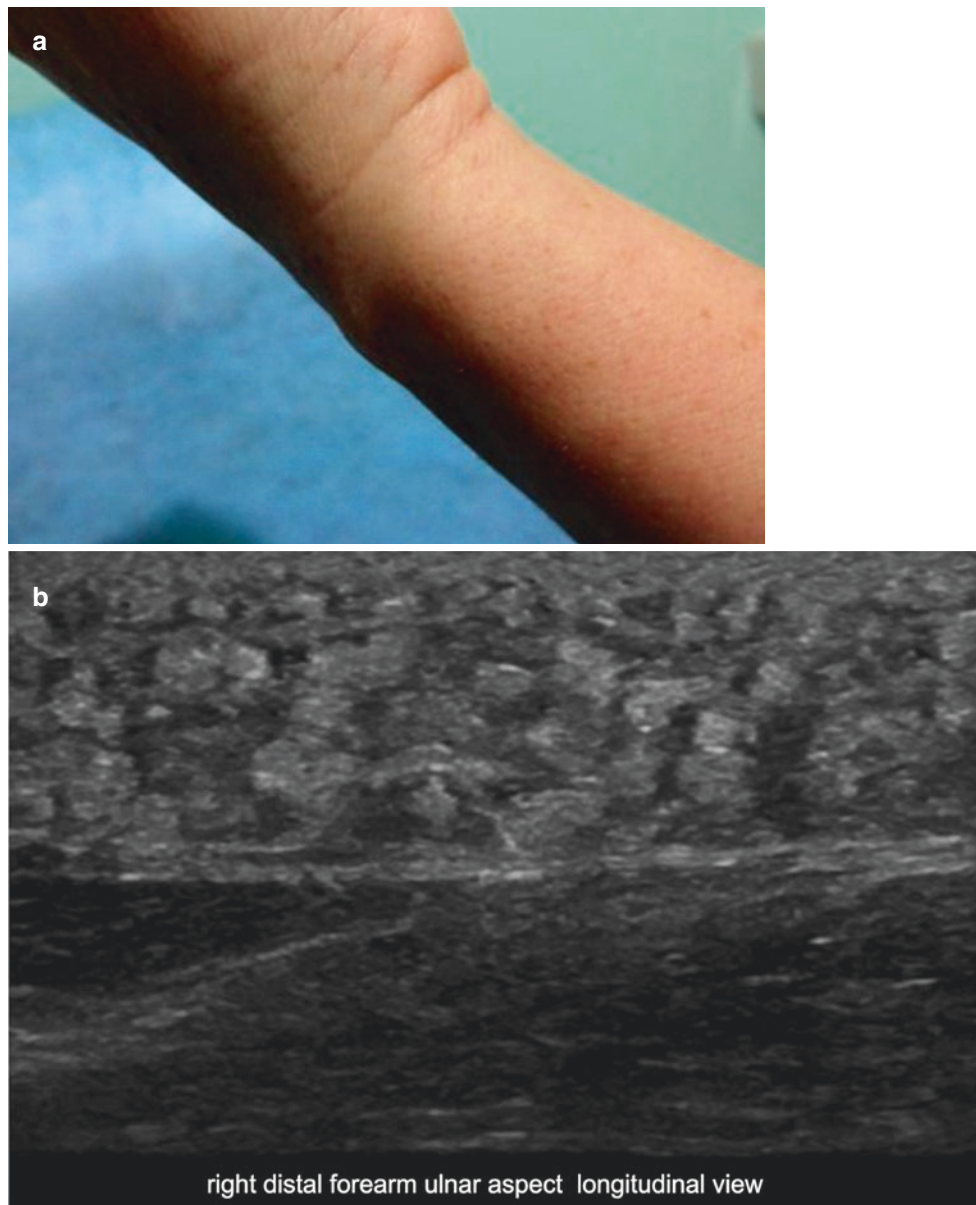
Mostly septal panniculitis (granulomatous origin). (a) Clinical site of the lesion in the distal and ulnar aspect of the right forearm. (b, c) Ultrasound (longitudinal views; (b) greyscale, and (c) panoramic greyscale with color filter) demonstrates prominent hyperechoic
